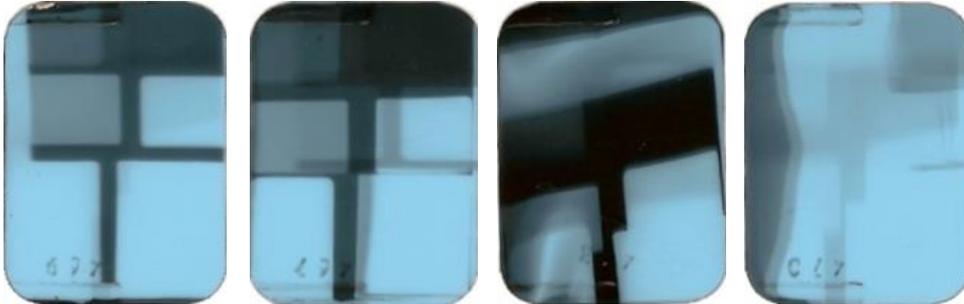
Film negligently exposed to an x-ray generator.
